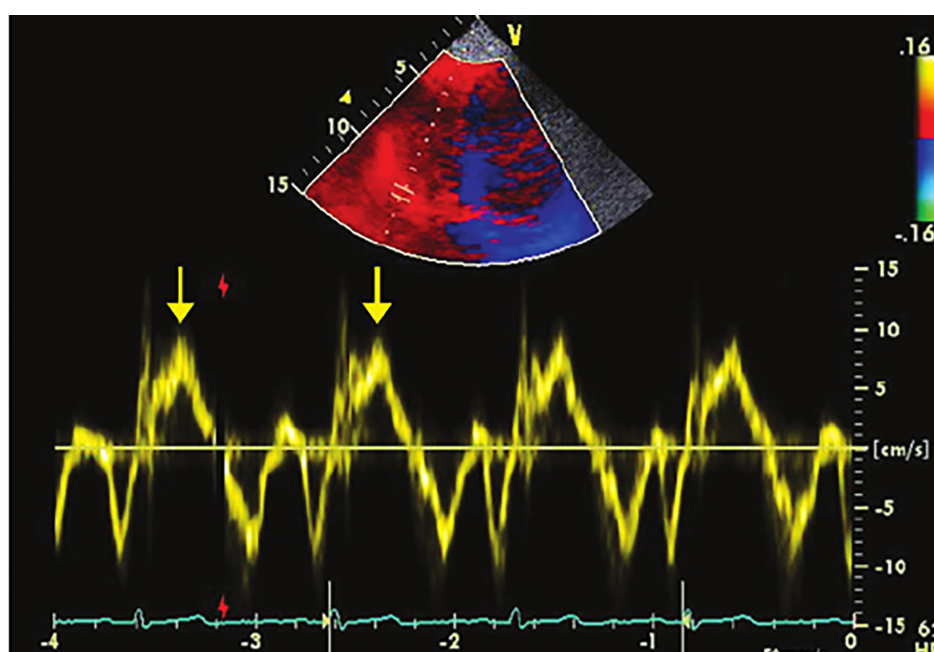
Measurement of the Lateral Tricuspid Annular Tissue Doppler Velocities
